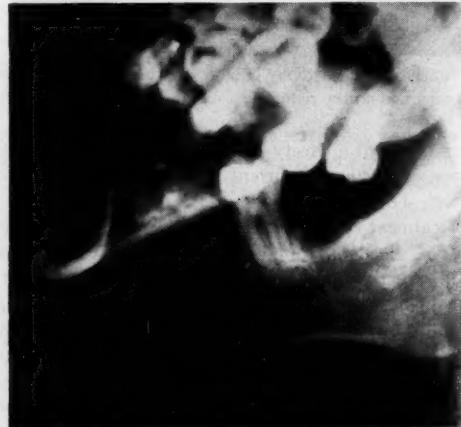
Roentgenogram taken 12 weeks after operation
